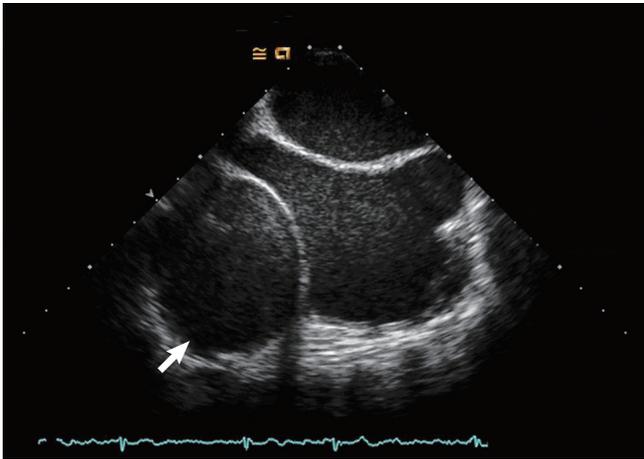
Two-dimensional transesophageal echocardiographic view of the left ventricular pseudoaneurysm (arrow).
